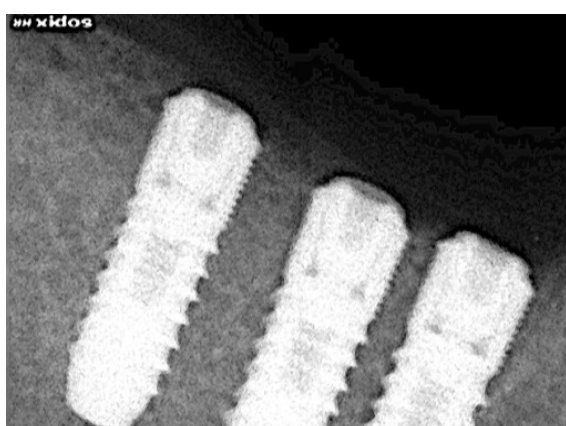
Radiograph after implant insertion
